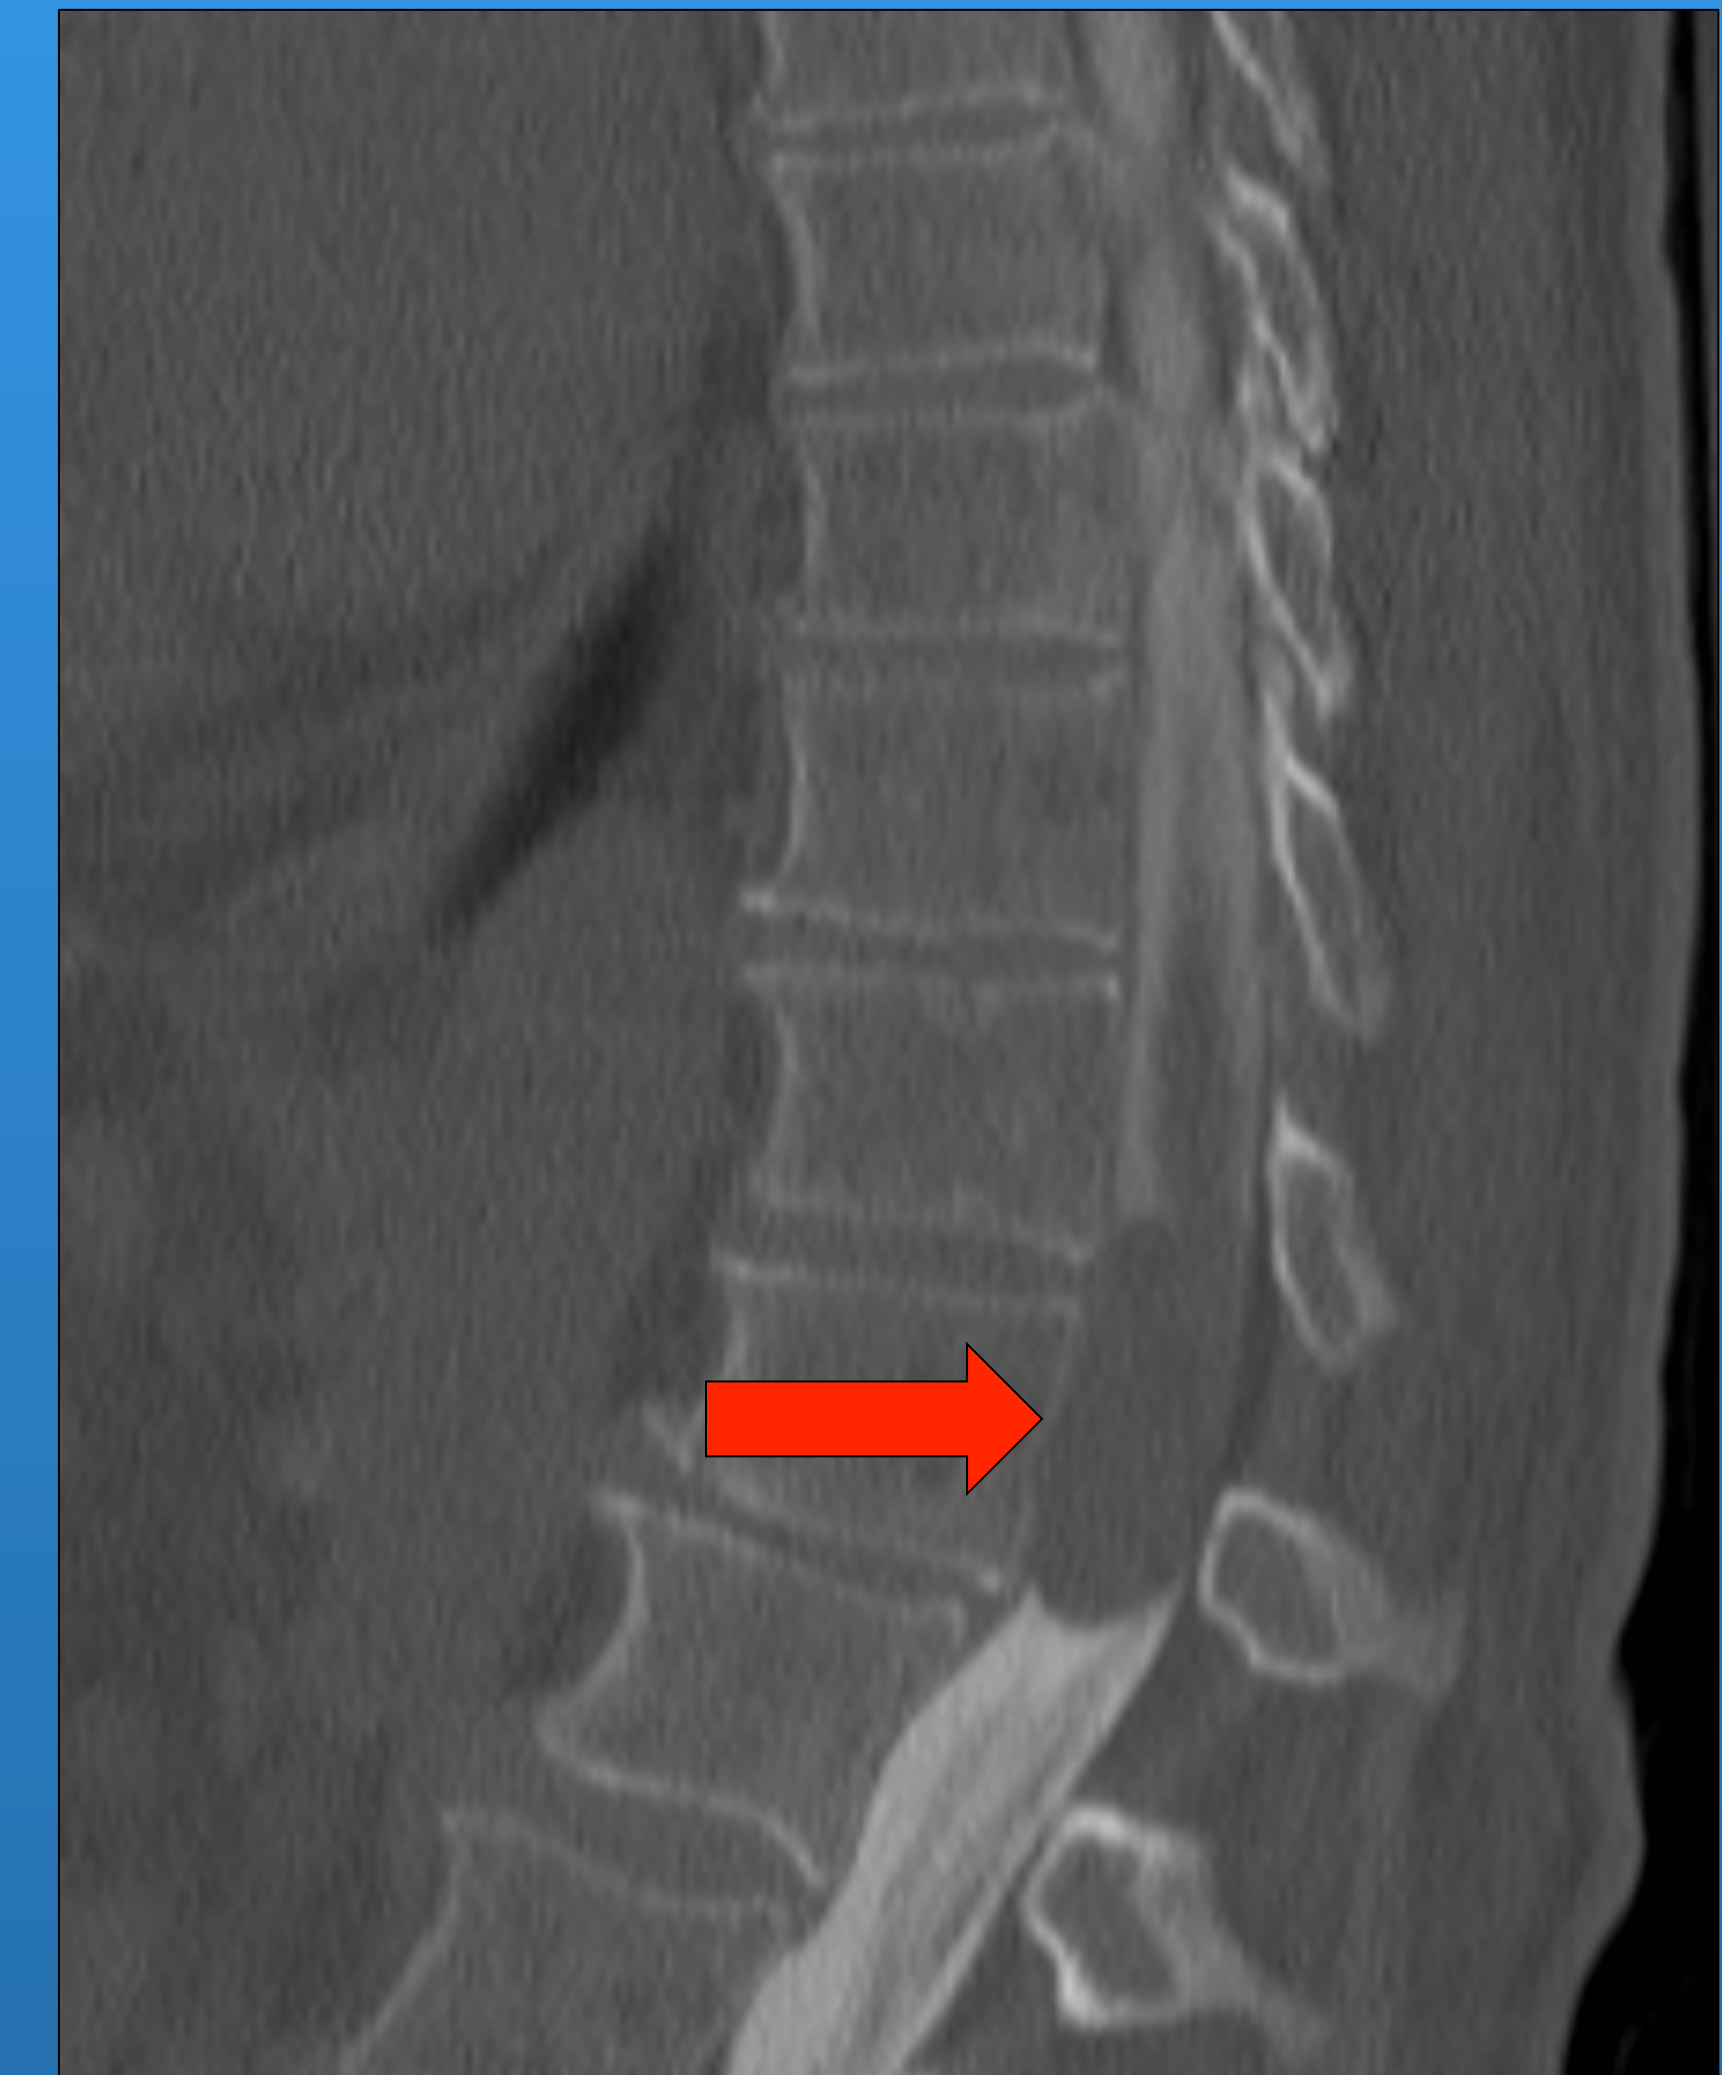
CT Myelogram with intradural mass
